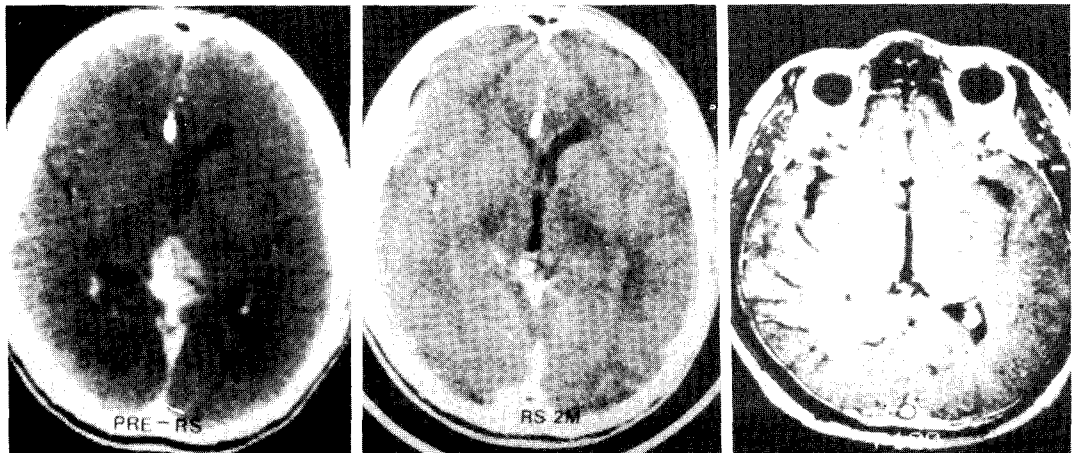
Pre-radiosurgery contrast enhanced C-T scan showed pineal tumor. Pathology was confirmed as mixed glioma by stereotactic biopsy (left). C-T scan at 2 months after radiosurgery revealed complete disappearance of tumor (middle). Newly developed small nodule on pineal area was shown on MRI at 21 months after RS (right).
